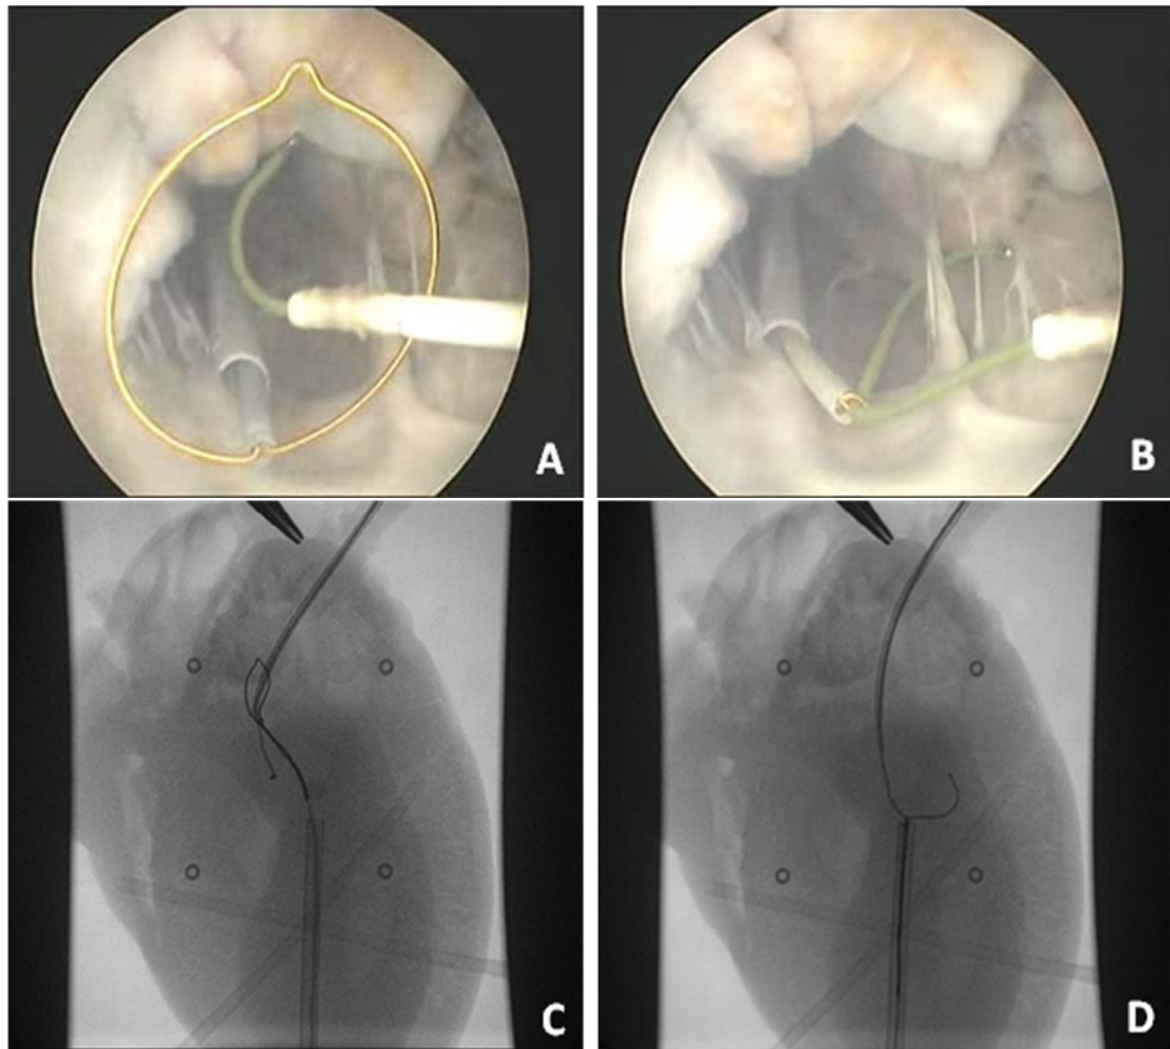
A, B: snare capture under endoscopic view. C, D: snare capture under X-ray visualization.
